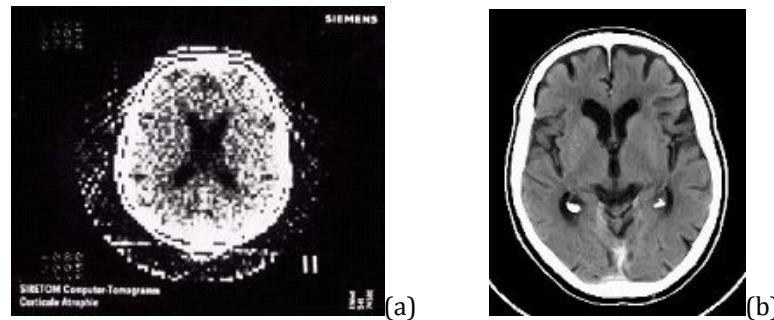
Brain CT image: (a) Axial CT image from Siretom CT scanner circa (1975); (b) Axial CT image using a modern scanner[13].
